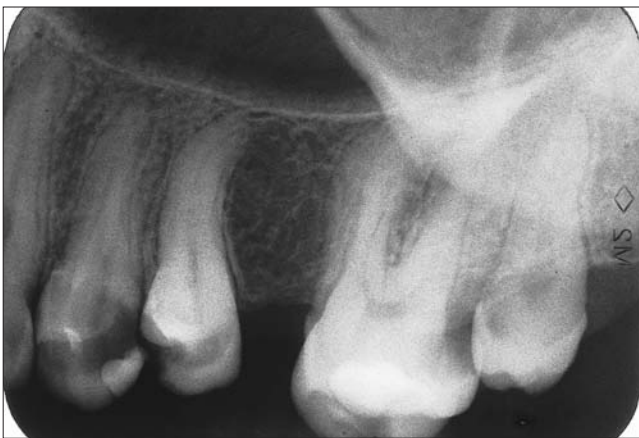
Preoperative radiograph of maxillary left second molar.
